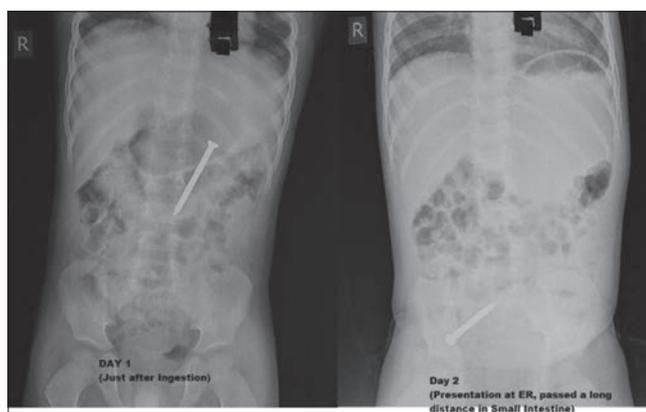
Serial X-ray of ingested FB (nail) shows gradual movement without symptoms. FB: Foreign body
